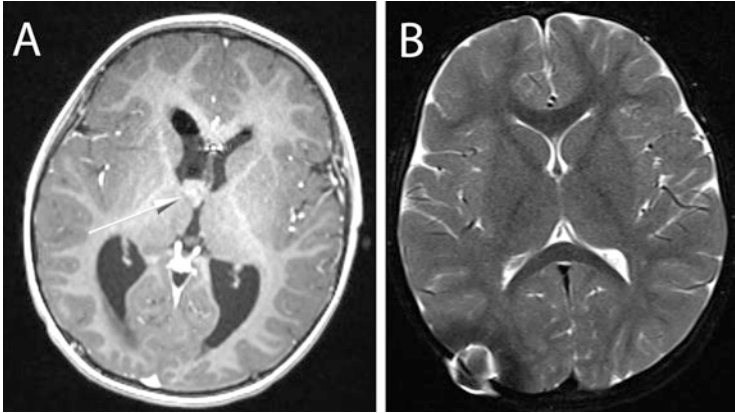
A 35-month old child presented with rapid progression of hydrocephalus. A T1-weighted MRI with gadolinium contrast shows an obstructive lesion at the level of the foramen of Monroe (a). This lesion was removed with a right frontal neuroendoscopic approach. The endoscope allowed removal of the lesion with minimal trauma to the surrounding brain. The lesion was a choroid plexus papilloma, WHO Grade I. There is no residual or recurrent tumor at the level of the foramen seen on a follow-up T2 weighted axial MRI one year after surgery (b). The child did not receive adjuvant therapy. However, despite complete tumor removal, the child required a cerebrospinal fluid shunt to treat hydrocephalus
